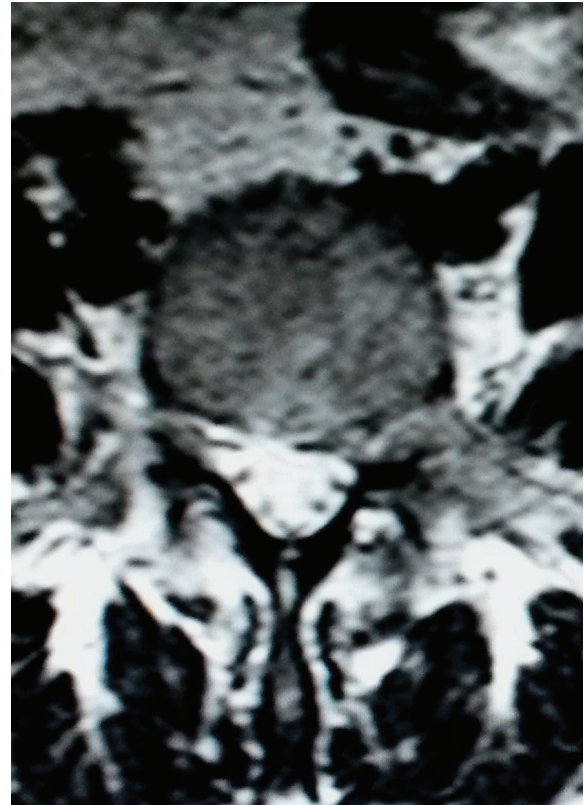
Control axial T2-Weighted MRI showed almost complete regression of the herniated nucleus pulposus at the L4-5 level
